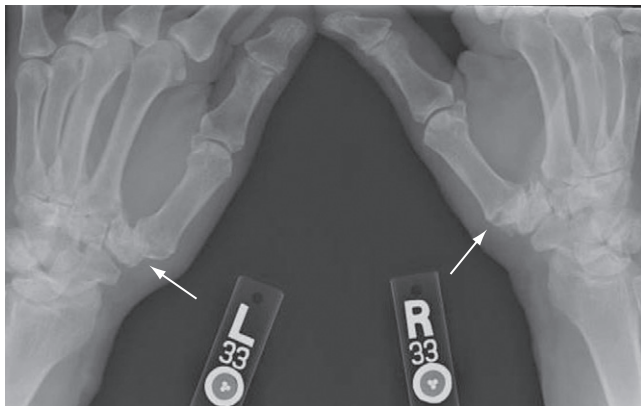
"Basal joint stress" radiograph showing stage 3 degeneration of the left thumb and stage 4 degeneration of the right thumb.
